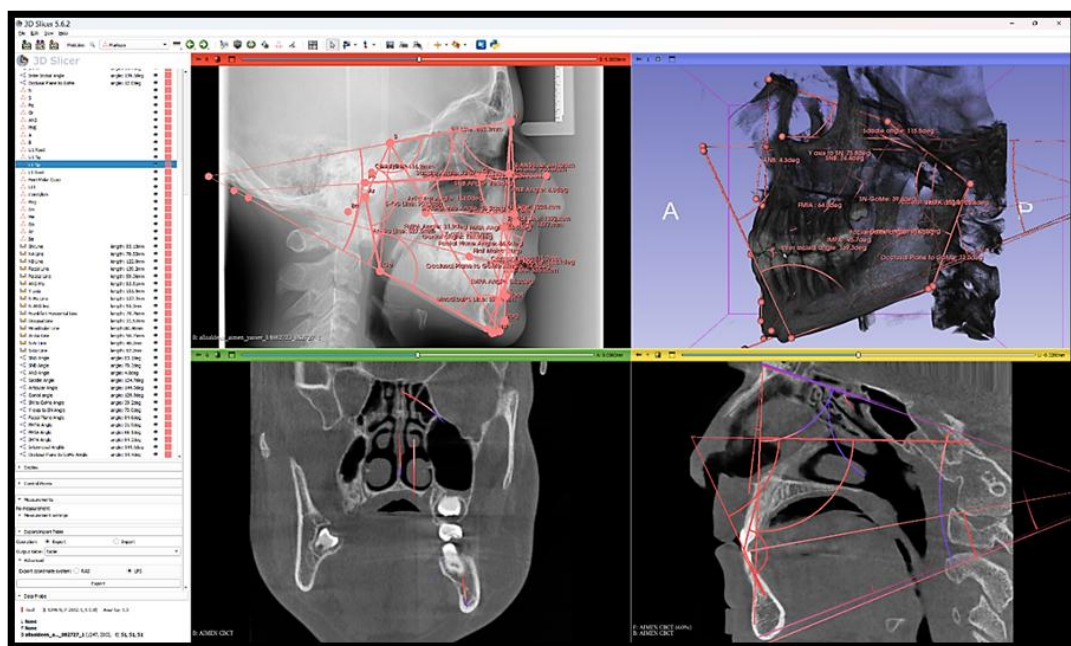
Conventional 2D lateral cephalometric analysis and CBCT 3D Slicer cephalometric analysis by 3D Slicer after registration process
